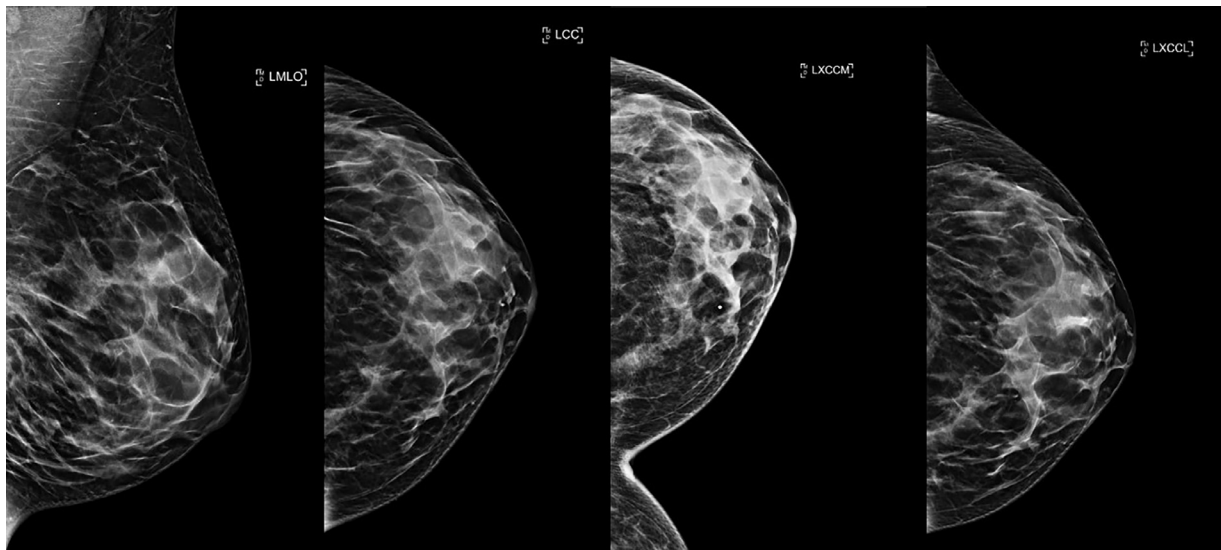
Mediolateral oblique, cranio-caudal, exaggerated cranio-caudal medial, and exaggerated cranio-caudal lateral views of the left breast are normal without evidence of the mass seen on ultrasound.
